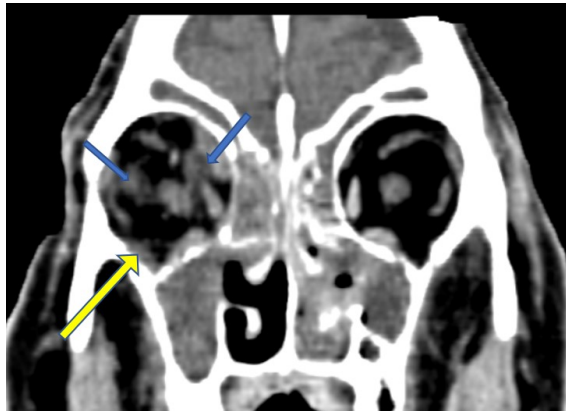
Coronal CT shows nodular thickening and stranding in right orbital fat involving both extraconal (yellow arrow) and intraconal (blue arrow) compartments.
